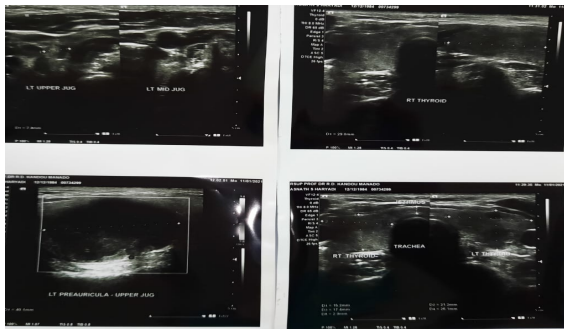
ultrasound well-defined anechoic cystic lesions with solid components inside
